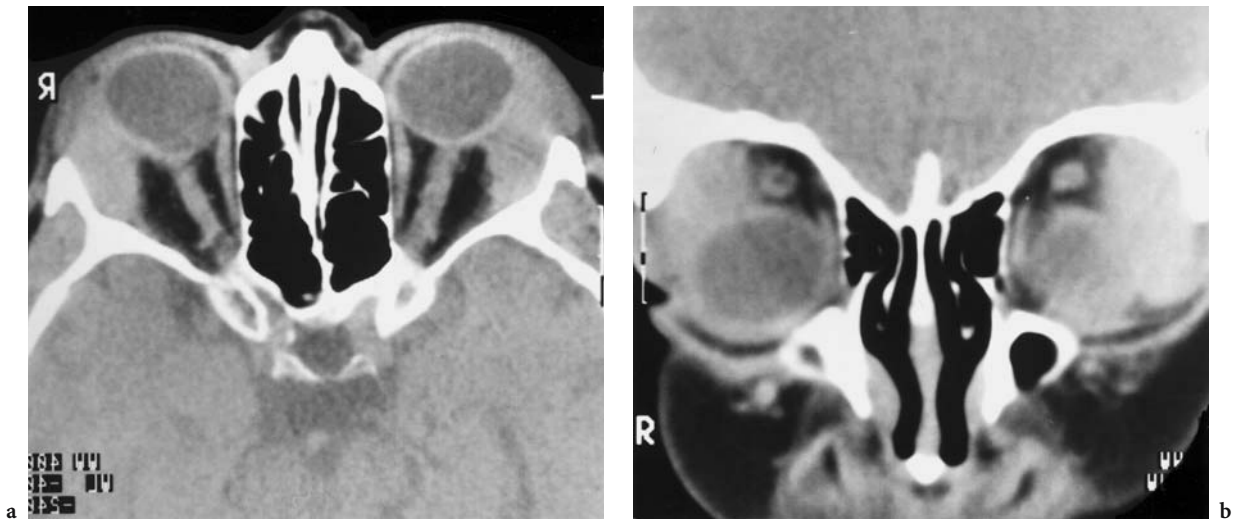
A 69-year-old woman with symmetric, bilateral, extra-axial proptosis. Diagnosis: bilateral lymphoma of the lacrimal gland. CT: a Axial native view with significant enlargement of the lacrimal glands, depressing both globes and flattening the circumference of the globes. b Corresponding coronal view. (With permission of MÜLLER-FORELL and LIEB 1995b)
